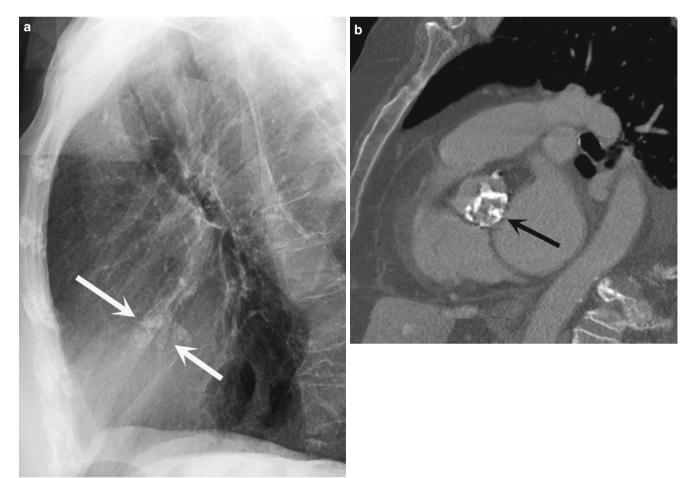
Lateral radiograph (a) and sagittal CT (b) show extensive aortic valvular calcification (arrows) in this patient with severe aortic stenosis
